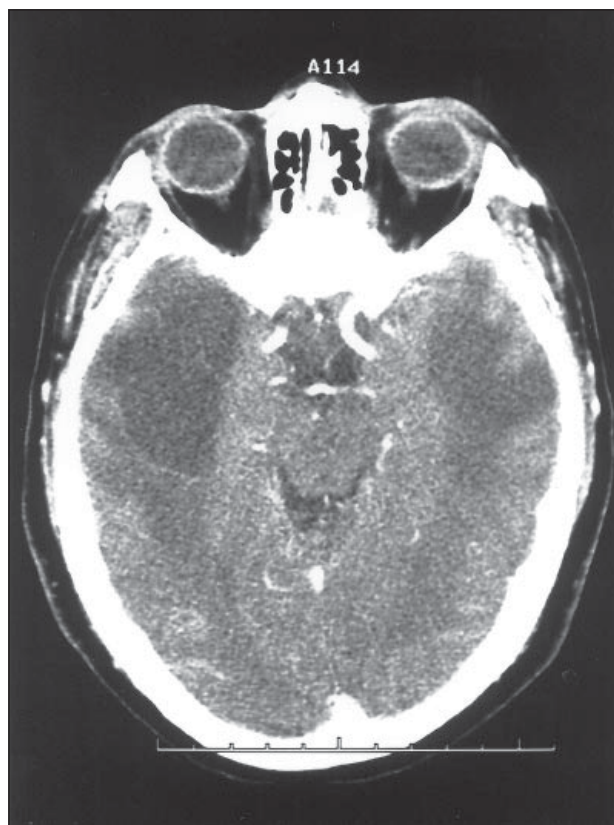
Computed tomography showing hypodense areas in bilateral temporal lobes with no significant mass effect and enhancement, representing typical bilateral temporal lobe necrosis.
